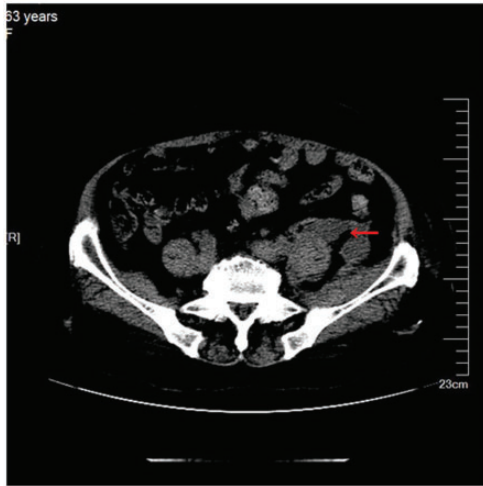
Computed tomography shows a dissolved and stabilized lower abdominal hematoma around the left iliopsoas muscle (red arrow).
